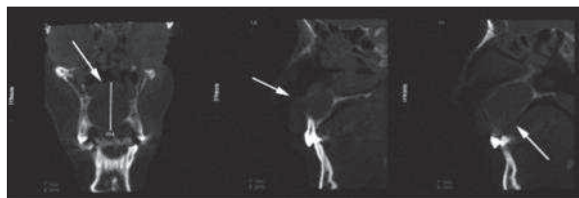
Elevated nasal floor on (A), buccal (B) and palatal bone (C) resorptions on are revealed by CBCT scan images.
